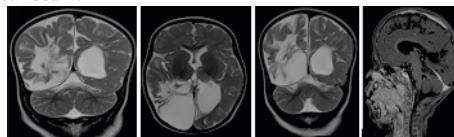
MRI coronal and axial images showing gliosis, porencephalic cyst, dilated ventricle, neuroparenchymal volume loss and non visualization of posterior body and splenium of corpus callosum.
